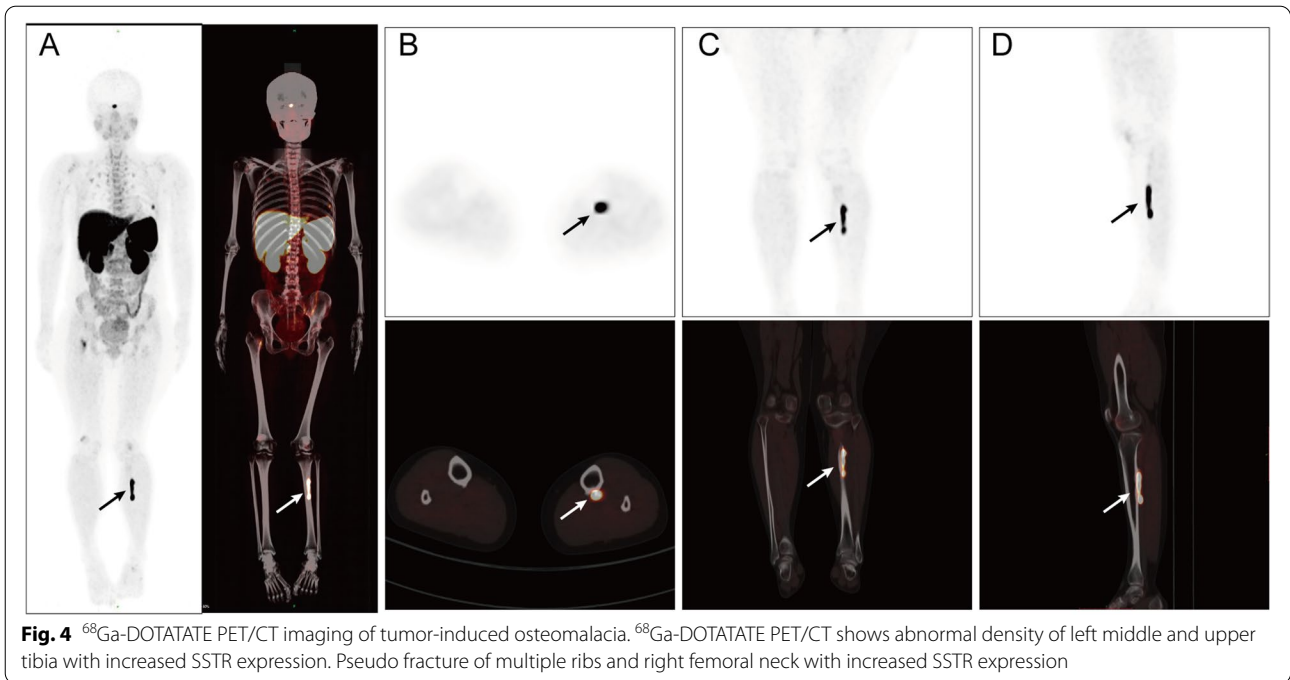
⁶⁸Ga-DOTATATE PET/CT imaging of tumor-induced osteomalacia. ⁶⁸Ga-DOTATATE PET/CT shows abnormal density of left middle and upper tibia with increased SSTR expression. Pseudo fracture of multiple ribs and right femoral neck with increased SSTR expression
